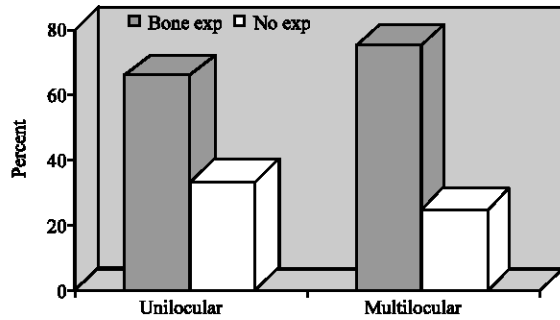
Relation between bone expansion and radiographic feature
